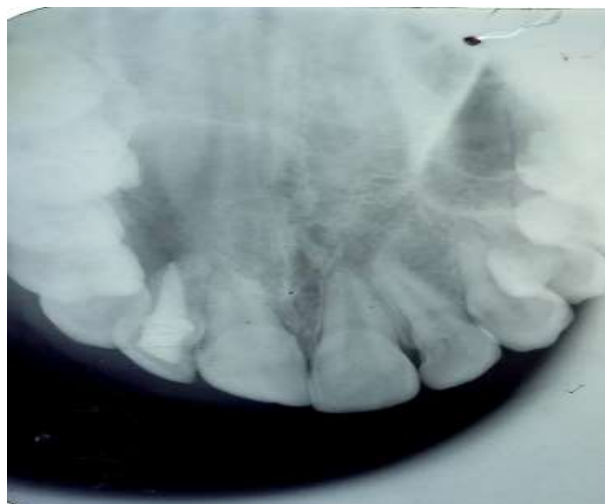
Occlusal radiograph.
